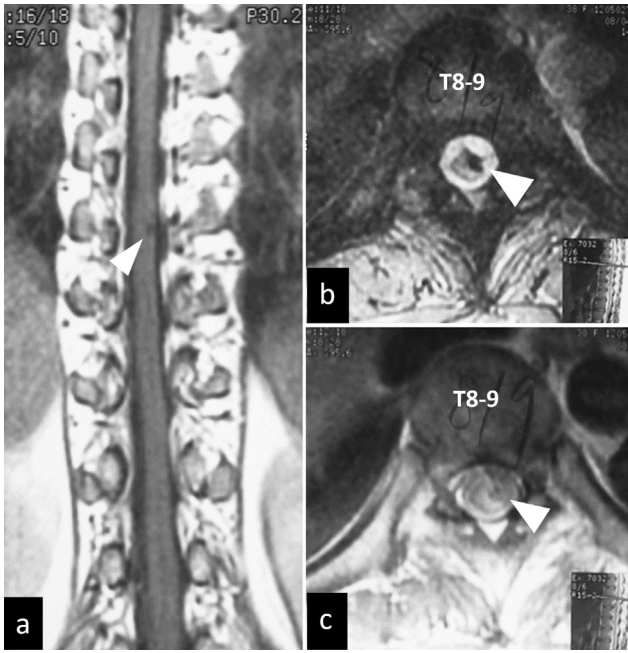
Magnetic resonance imaging of the thoracic spine obtained 2 years after endovascular treatment. (A) Coronal T1-weighted, axial (B) gradient recalled echo (GRE) T2*-weighted, and (C) proton density (PD)-weighted images demonstrate hypointensity (arrowheads) at the level of T8–9 on the left anterolateral part of the spinal cord, probably corresponding to hemosiderin.
